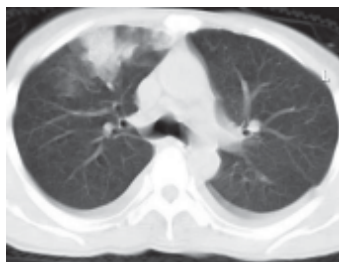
Spiral CT through the upper chest reveals a pleural based wedge shaped infarct in the anterior segment of the right upper lobe.
